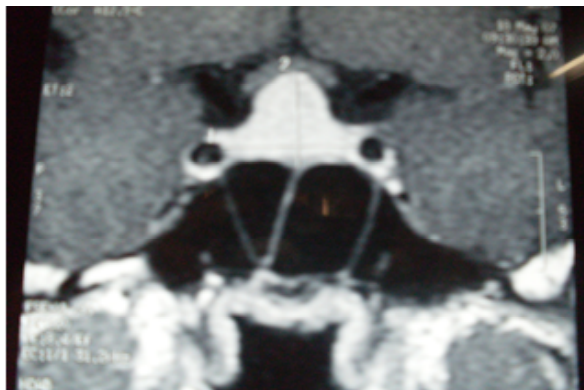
MRI of sella displaying a homogeneous mass suggestive of a pituitary macroadenoma measuring $22 \times 18 \times 16$ mm³, with suprasellar extension and mass effect on the optic chiasma
